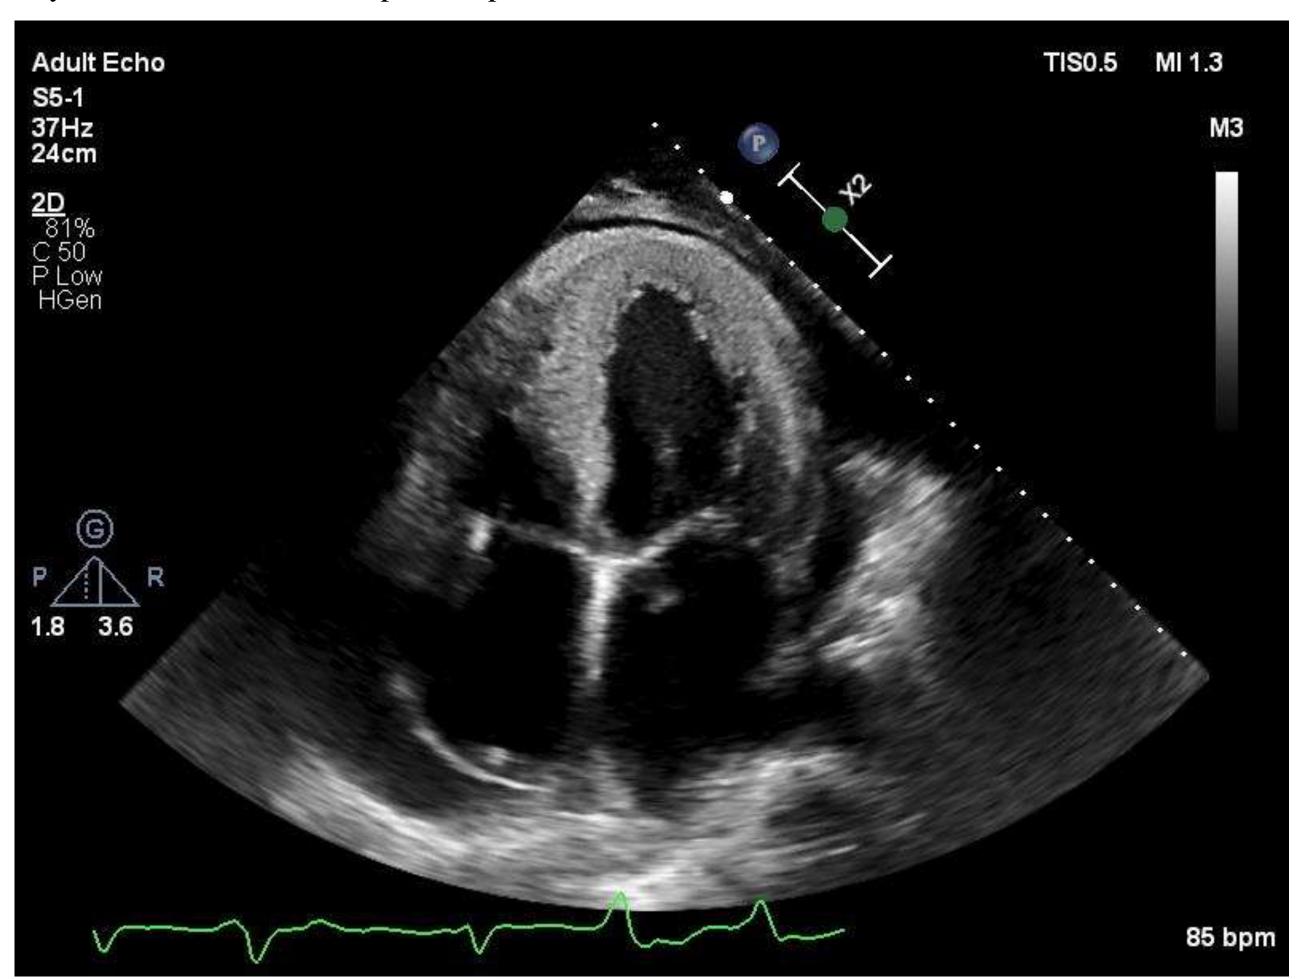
Transthoracic echocardiogram in 4 chamber view demonstrating increased myocardial thickness and biatrial enlargement.
